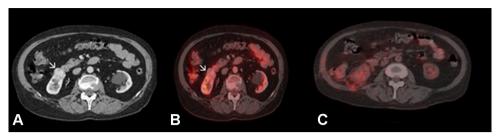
Positron emission tomography-computed tomography (PET-CT) in a 65-year-old woman with rectal cancer and a history of anterior rectal resection. Transaxial axial CT (A) and fused PET/CT (B) showed FDG non-avid lesion in the right kidney, highly suspicious for the second primary tumor. C) Transaxial fused PET-CT showing postoperative changes after biopsy confirmation of cancer and partial resection of the right kidney.
